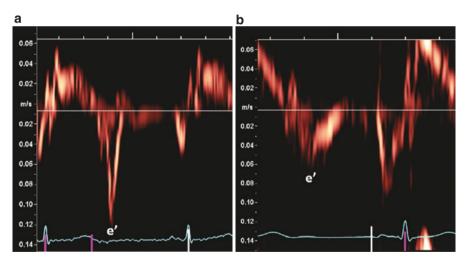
Tissue Doppler imaging at the medial mitral valve annulus lateral showing normal velocity (a) and reduced velocity (b) through the cardiac cycle
